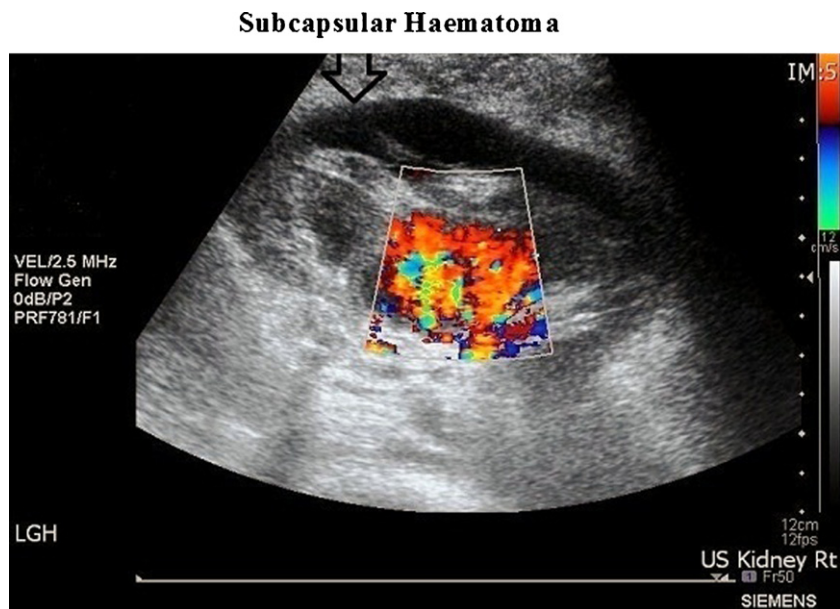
Doppler ultrasonography of the renal allograft showing a haematoma; and a normal blood flow in the hilum.
